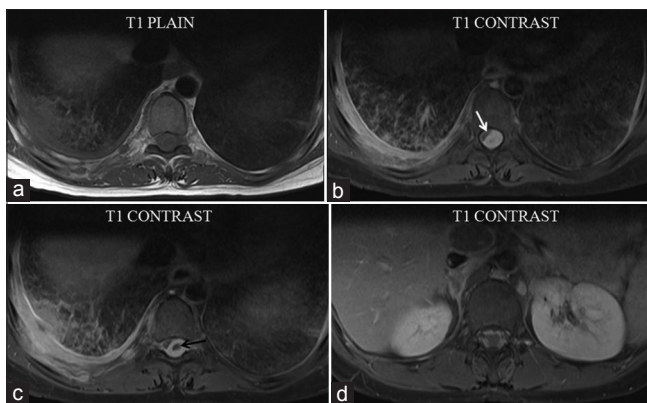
MRI thoracic spines - (a) T1 weighted axial sequence and (b and c) Post-gadolinium T1 weighted axial sequence showing a dorsolaterally placed enhancing IDEM lesion with a central non-enhancing area (black arrow) within. Lesion is pushing the cord (white arrow) to right. Visualized lung parenchyma shows miliary mottling and right pleural effusion. (d) Thin layer of enhancing lesion is seen encasing the lower end of the cord
